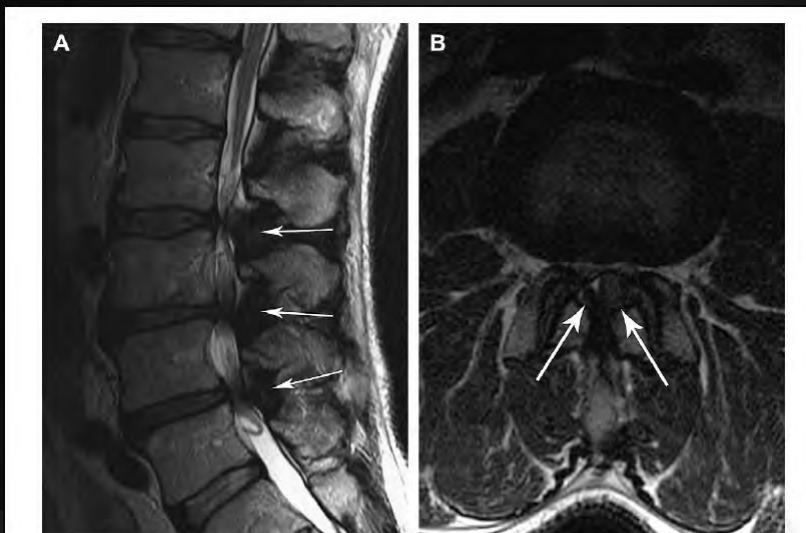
Facet joint osteoarthritis and spinal stenosis. A 67-year-old man with low back pain and weakness in both legs exacerbated with walking. Sagittal (A) and axial (B) FSE T2-weighted MR images demonstrate multilevel loss of disc space height with resultant redundancy of the ligamentum flavum (arrows), causing severe spinal stenosis at each level.
